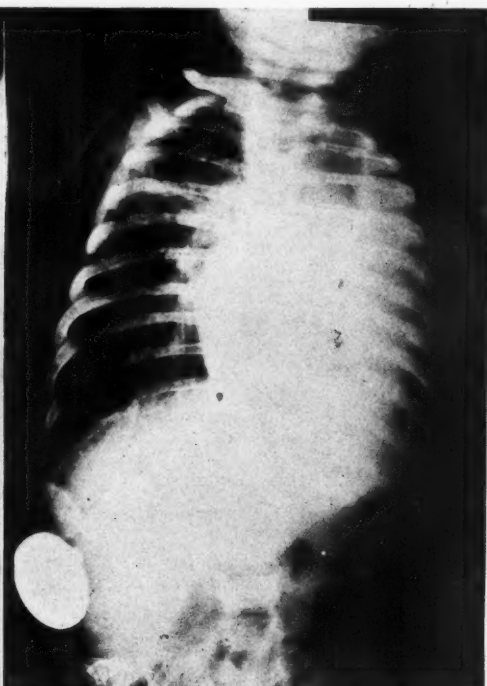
The term "massive atelectatic collapse of the lung" should be reserved for instances where previously well aerated lung undergoes sudden collapse without bronchial obstruction or other apparent cause. This film shows practically the same X-ray findings, but the condition is one of congenital atelectasis.
